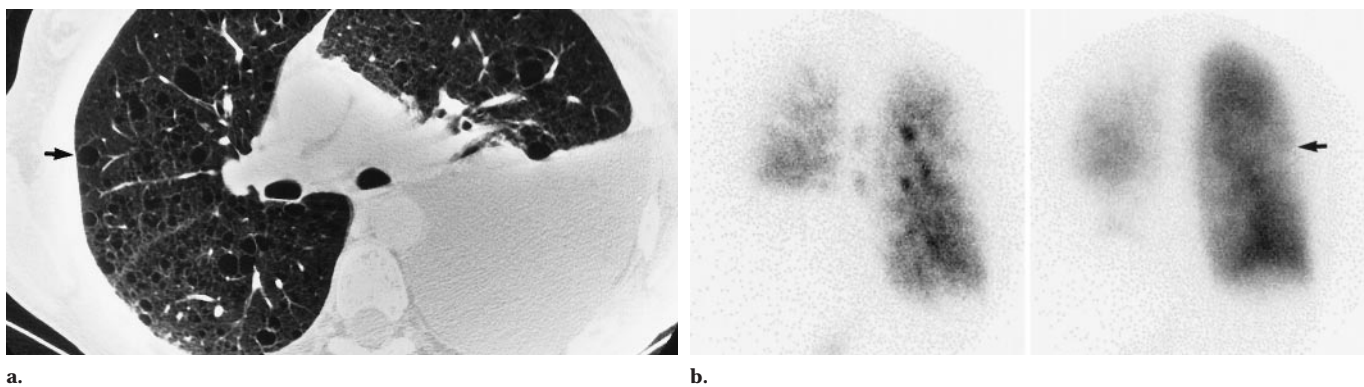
Lymphangioleiomyomatosis in a 54-year-old woman. (a) Transverse thin-section CT scan and (b) posterior ventilation (left) and perfusion (right) images show the moderate extent of disease visible on the CT scan, which consists of pulmonary cysts (arrow in a) involving 30%–60% of the lungs; mild ventilatory abnormalities, aside from the defect caused by pleural effusion; moderate perfusion defects (arrow in b); and moderate speckling consisting of focal areas of increased uptake of radionuclide in the lungs.
